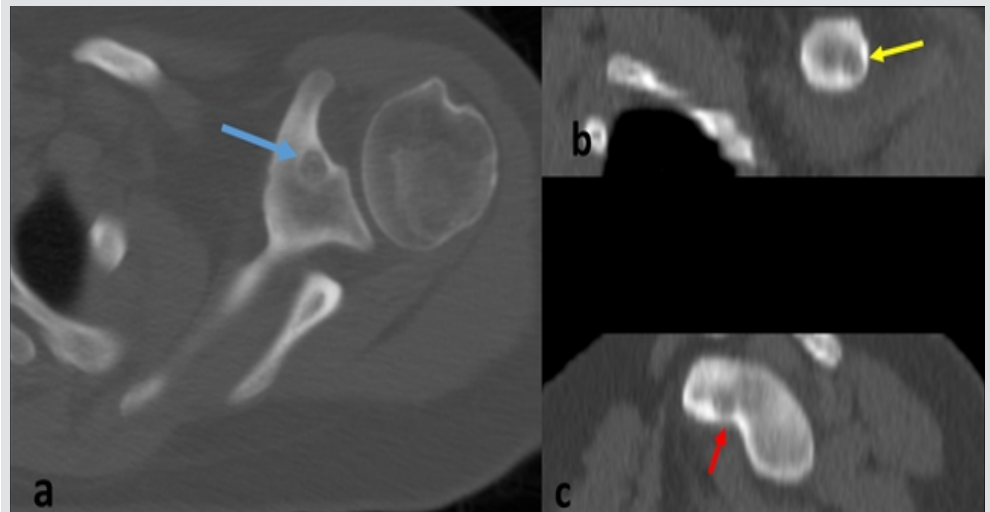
Axial view (a) of computed tomography scan of the left shoulder showing a round well-defined lesion localized in the scapular neck with a focal lucent nidus within surrounding sclerotic reactive bone measuring 8.5 mm in largest diameter (blue arrow), compatible with osteoid osteoma. (b) Coronal view showing the same lesion (yellow arrow). (c) Sagittal view.
